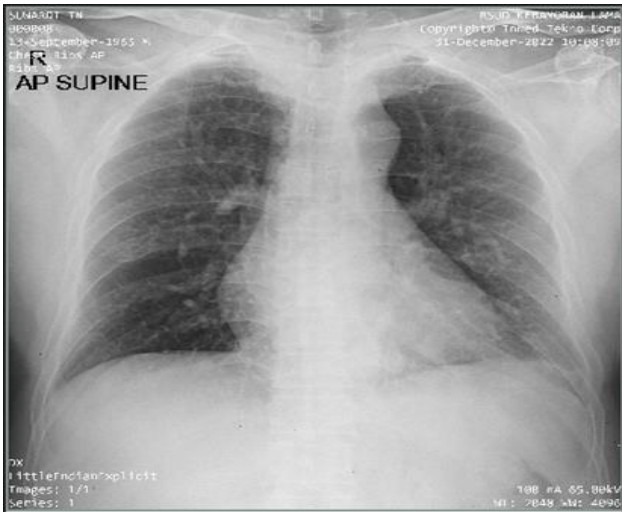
Chest X-ray showing cavity on left lung lower zone suggesting cavitating mass or lung abscess. Chest X-ray also suggesting pulmonary tuberculosis with minimal left pleural effusion.
